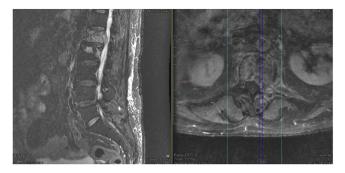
Sagittal (left image) and axial (centre image with cut at L1) T2-weighted sequence of dorsolumbar MRI showing metastatic lesions at L1 and L2 with compression of the conus medullaris at L1 level by tumour mass anterior to the thecal sac and by left pedicle invasion.
